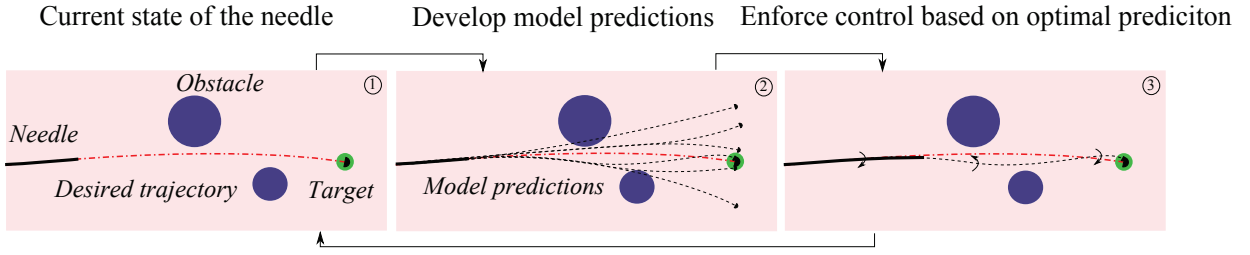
Ultrasound-guided model predictive needle steering steps. (1) The current position of the needle tip is estimated from ultrasound images. (2) The position of needle tip is used as initial condition in the needle steering model. Since the model accepts needle axial rotation as an input, an optimization algorithm is used to generate multiple needle tip trajectories corresponding to needle rotation at various future depths. (3) The closest path to the desired trajectory that has the minimum amount of tissue deformation and the least number of needle rotations is selected as the optimal path. The control input (depth of axial rotation) corresponding to the optimal path is used to steer the needle. Since the needle tip will inevitably deviate from its model prediction because of tissue inhomogeneity and uncertainties in model parameters, the above MPC loop is repeated to continually monitor and compensate for needle tip deviations.
